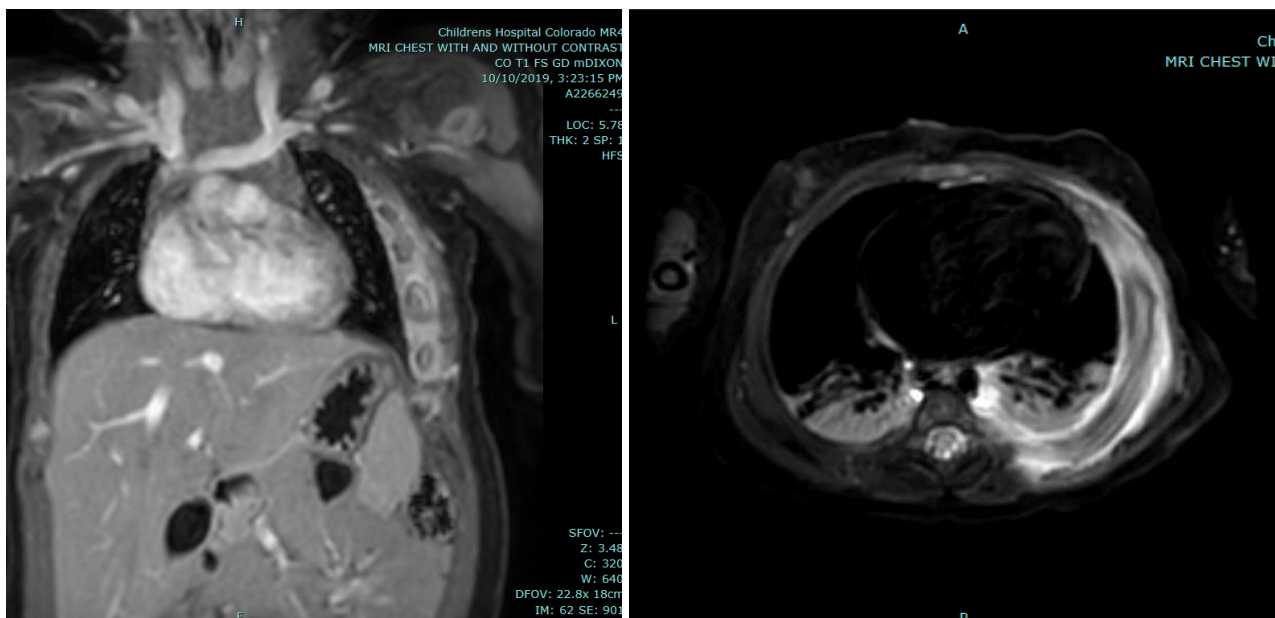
MRI of the chest revealing abnormal signal of left chest wall, including the ribs, intercostal musculature and overlying soft tissues.
